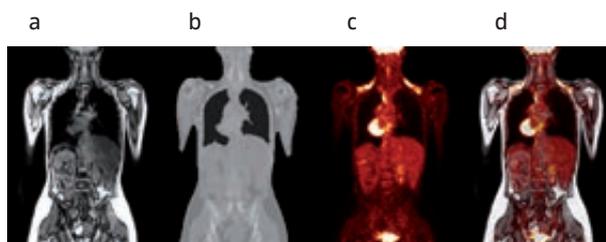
Example of MR-based attenuation correction on a pediatric patient. a) In-phase MR image that was used to create the MR-based attenuation map (b). c) [^{18}F]FDG PET image reconstructed using the MR-based attenuation map and d) fused PET and in-phase MR image.
